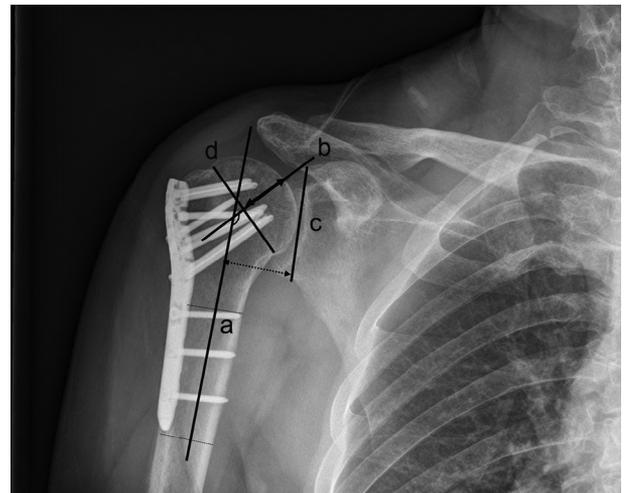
Radiographic measurements on anteroposterior view of shoulder. Line *a* bisects the humeral shaft. Line *d* is the line between the superior and inferior borders of the articular surface. Line *b* is the line perpendicular to line *d*. Line *c* is the line parallel to line *a* and is the tangent line of the articular surface. The angle between lines *a* and *b* was defined as the neck-shaft angle (*semicircle*). The humeral head offset is the distance between lines *a* and *c* (*dotted arrow*). The longest line from the articular surface to line *d* is the humeral head thickness (*solid arrow*).
